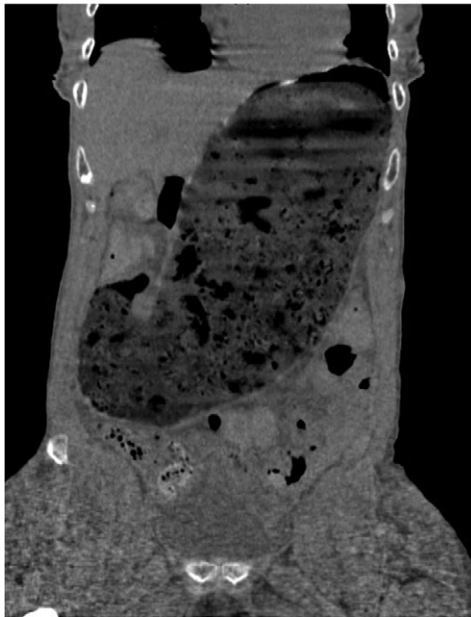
Computed tomography scan at presentation (prior to perforation) demonstrating gastric distention secondary to amyloid provoked gastroparesis with fecalization of gastric contents.
